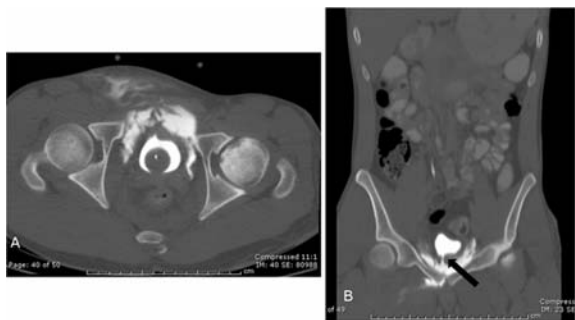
Grade 5 urinary bladder injury. A 20-year-old male presented with motor vehicle accident. A: Axial CT scan on delayed phase (bone window) shows contrast extravasation into prevesical space and anterior lower abdominal wall, representing extraperitoneal bladder rupture. B: Coronal reconstruction shows the ruptured site at bladder base (arrow).
